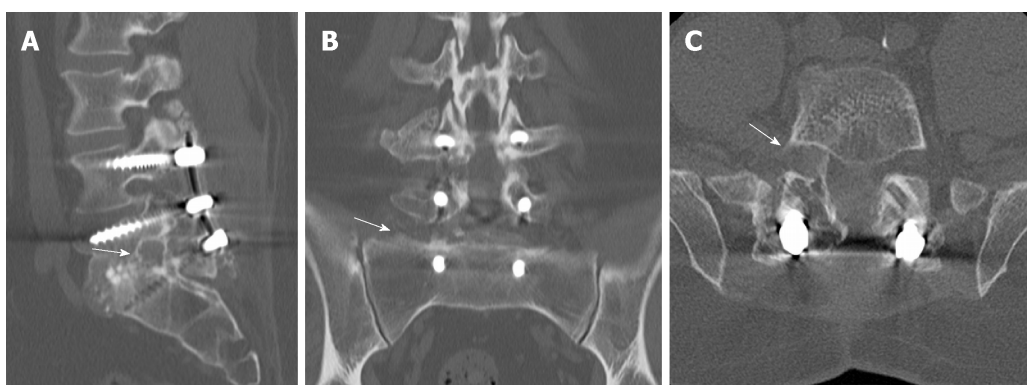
One-year post-operative computed tomography-scan. A: Sagittal, B: Coronal; C: Axial. No foraminal bone fragment or stenosis (arrows).
